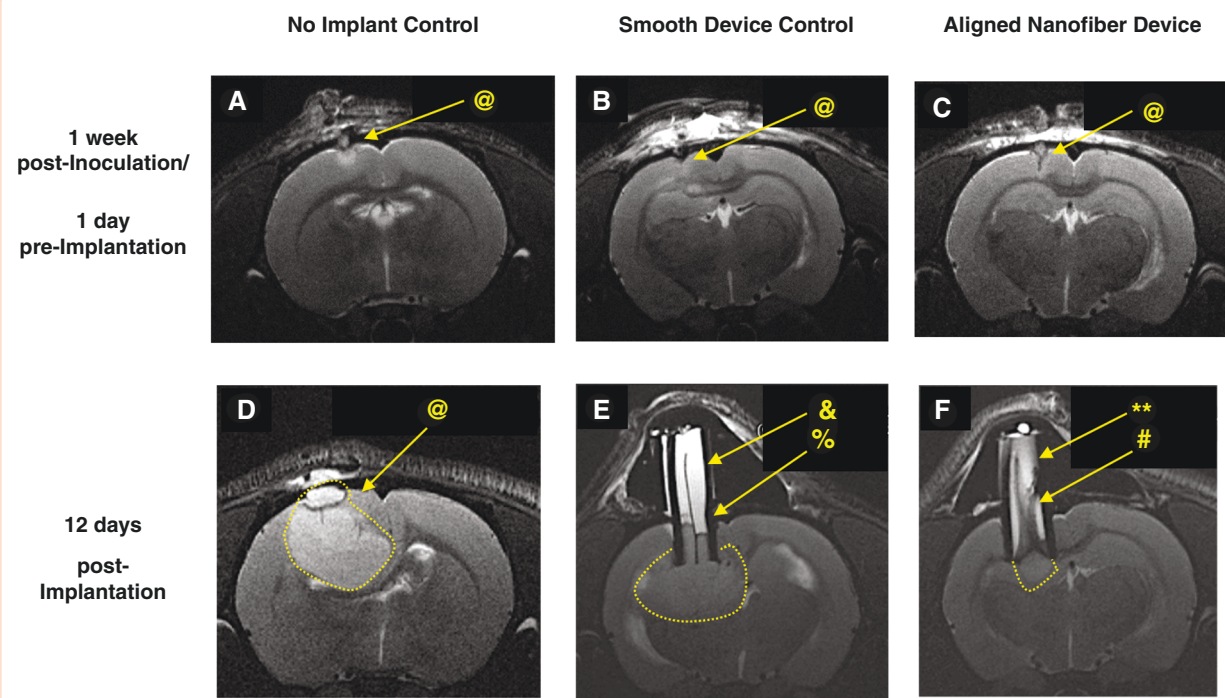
Representative T2-weighted MR images of U87MG model pre- and post- device implantation showing no adverse response to implant while confirming the possibility of noninvasive monitoring of tissue migration inside the device. (@: tumor, &: fluid, %: edge, : flow voids, #: gradient). One week post-inoculation: (A) no implant control, (B) smooth film device control, (C) aligned nanofiber device. 12 days post-device implantation, (D) no implant control, (E) smooth film device control, and (F) aligned nanofiber device. In D, E, and F, tumor is surrounded by dotted white lines, bright white content inside device is fluid, and tissue inside device appears in gray tones. In (E), separation between tissue (gray) and fluid (white) is outlined by a dark edge between the two (%). Smooth film appears as a dark line at the center. In (F), inside the aligned nanofiber device, gray strips indicative of tissue appears along almost the entire length of device, and there is no well-defined edge separating the fluid inside the device from tumor. Flow voids () indicating interactions between tissue and fluid inside the aligned nanofiber device are visible.
